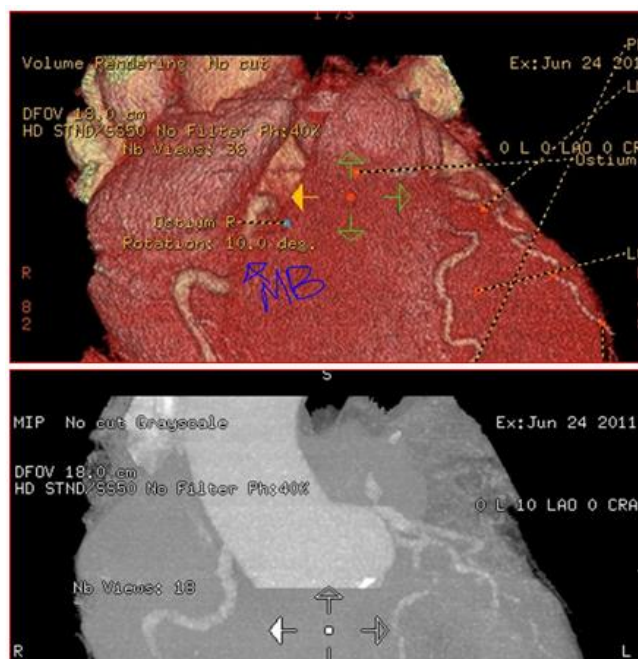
CT Coronary angiogram of index case
